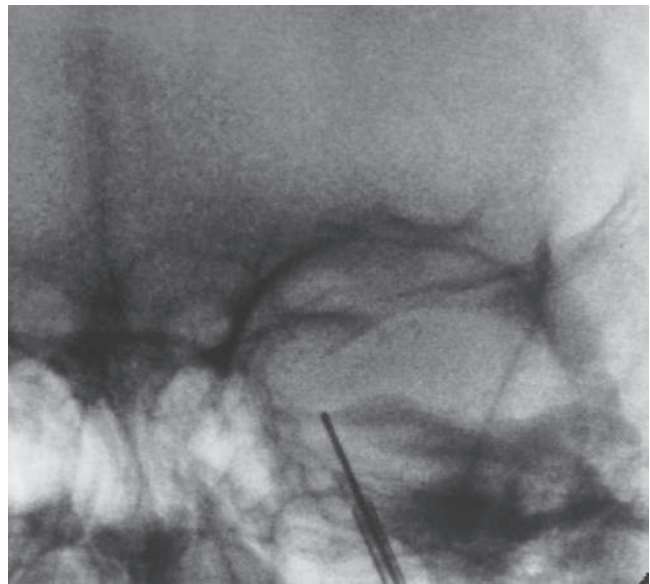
Modified anterior-posterior radiograph of the skull with the petrous bone aligned in the center of the orbit as viewed radiographically. The balloon tip is positioned in the center of the dip for optimal compression of second-division trigeminal pain.
